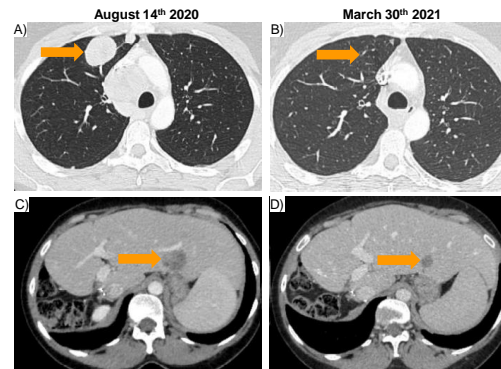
CT scans of a patient with HCC; A and B: lung before and after treatment with BI 765063, respectively; C and D: liver before and after treatment with BI 765063, respectively; BI 765063 monotherapy at 24 mg/kg (39 weeks of treatment, ongoing)
